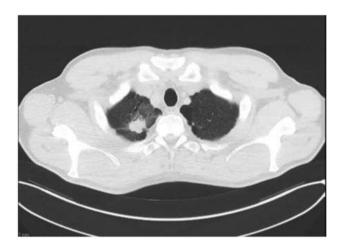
Lung computed tomography at cancer diagnosis showing a mass 43 mm long-axis diameter in the apical segment of the right superior lobe of the lung.
